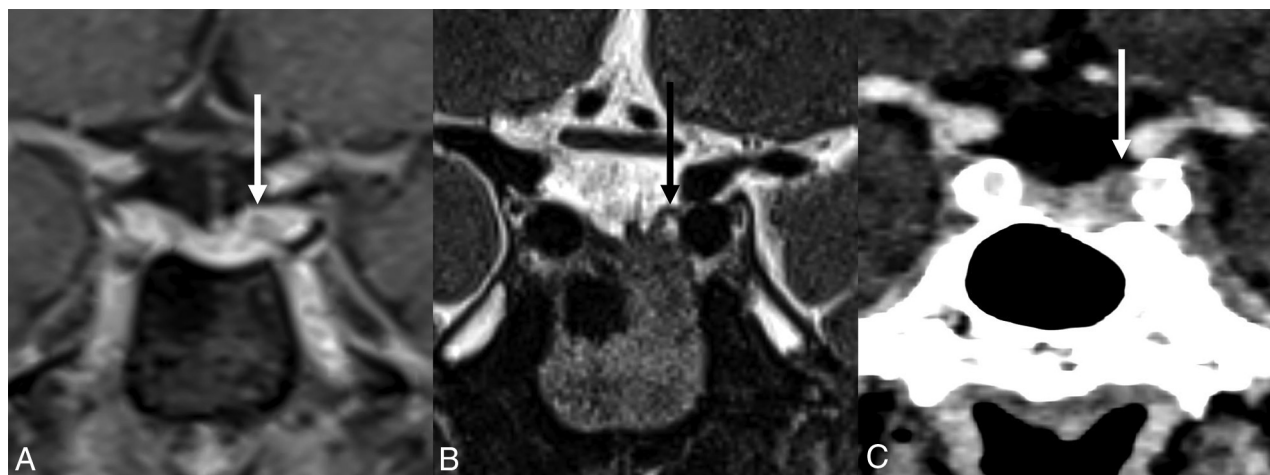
Patient 2, a 57-year-old woman with Cushing disease. Coronal dynamic contrast-enhanced MR imaging (A, *white arrow*) shows a small, hypoenhancing lesion in the left superior aspect of the pituitary gland with a corresponding T2-hyperintense signal (B, *black arrow*). PCD-CT (C, *white arrow*) shows corresponding hypoenhancement on the first series of the sella, seen as a coronal reconstruction at 0.6-mm section thickness.
